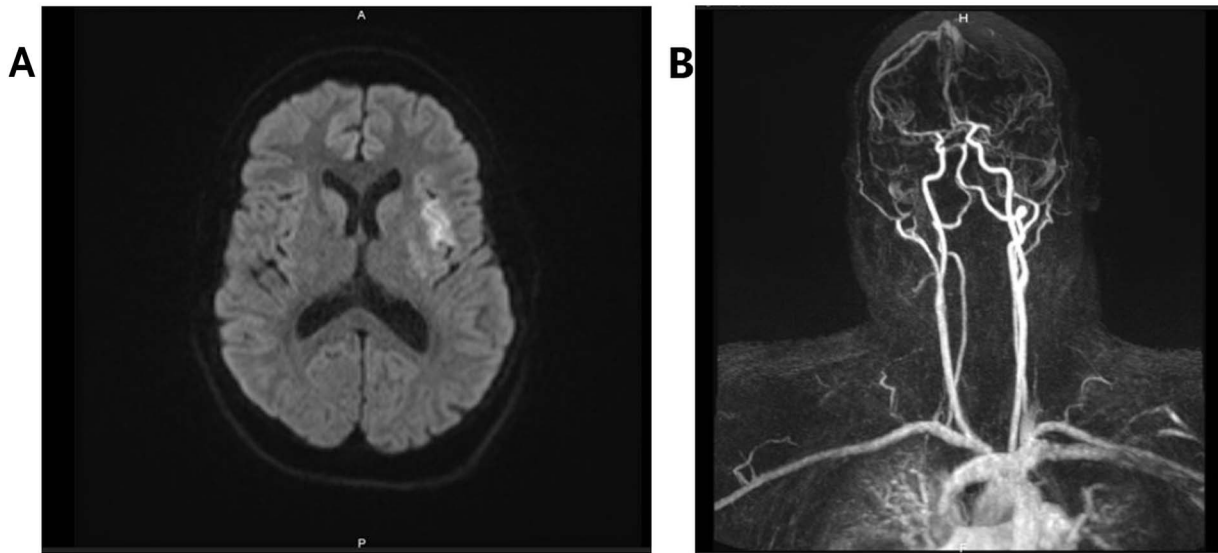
(A) MRI showed a recent infarct in the MCA territory (B) MRI showed an occlusion extending from the bifurcation to the M2 segment .
